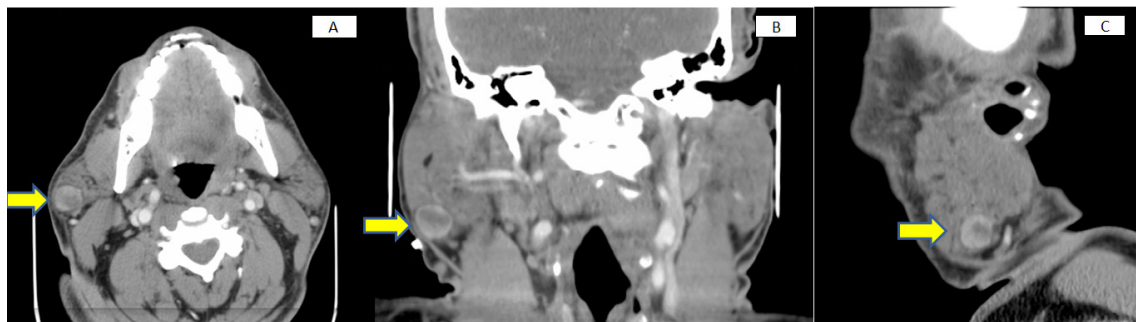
1.7cm right lower lobe parotid tumor seen on CT scan (A axial view, B coronal view, C sagittal view).
